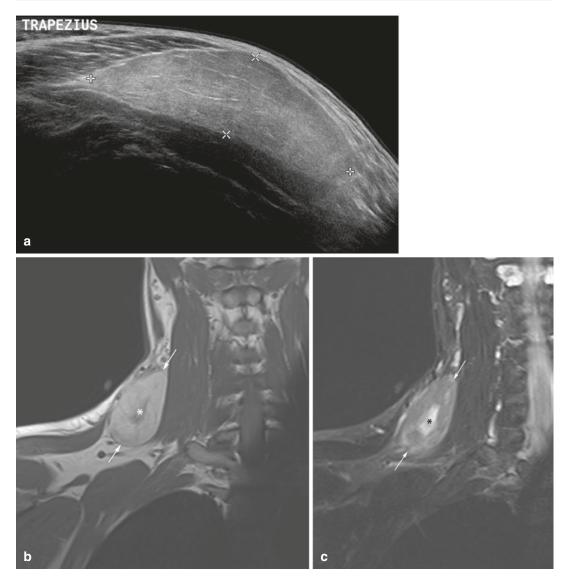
(a–c) Hibernoma of the neck. (a) Ultrasound. (b) Coronal SE T1-weighted MR image. (c) Coronal fatsuppressed SE T2-weighted MR image. The mass (*arrows*) shows homogenous hyperechoic fat signal on ultrasound, but MR images show a central area (*) of nonfat SI and altered fat signal in the majority of the lesion.
